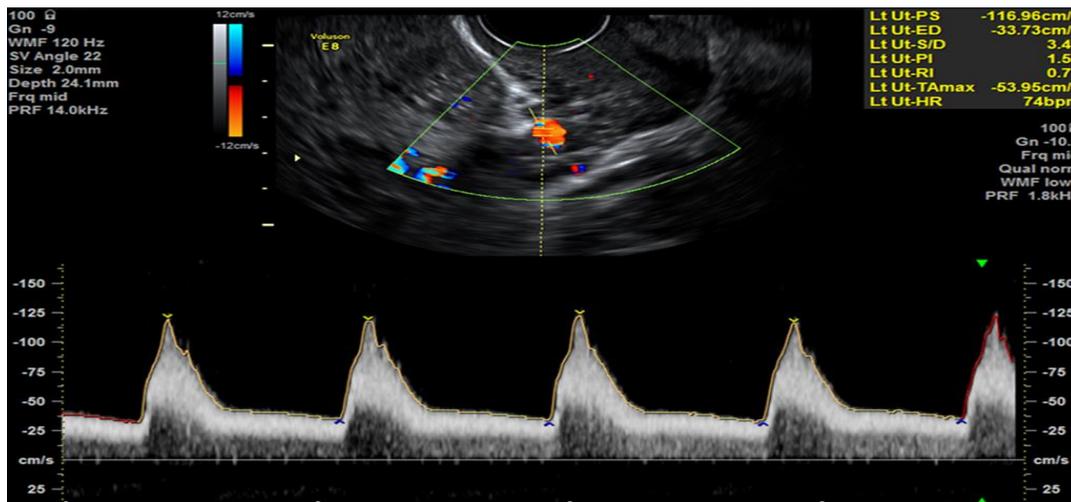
Pulsed color Doppler assessment of uterine artery RI and PI.
